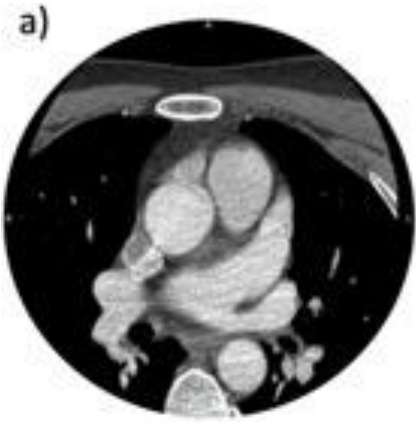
Example computed tomography (CT) angiography images of the three categories created while evaluating for thrombi: a) negative: the left atrial appendage (LAA) completely opacifies with contrast; b) indeterminate: does not fulfill either criteria; c) positive: well defined filling defect in the LAA (red circle).
